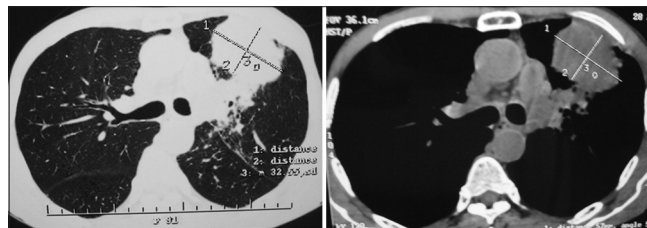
High-resolution computed tomography thorax showing mass lesion left lung upper lobe with the left main bronchus infiltration.
